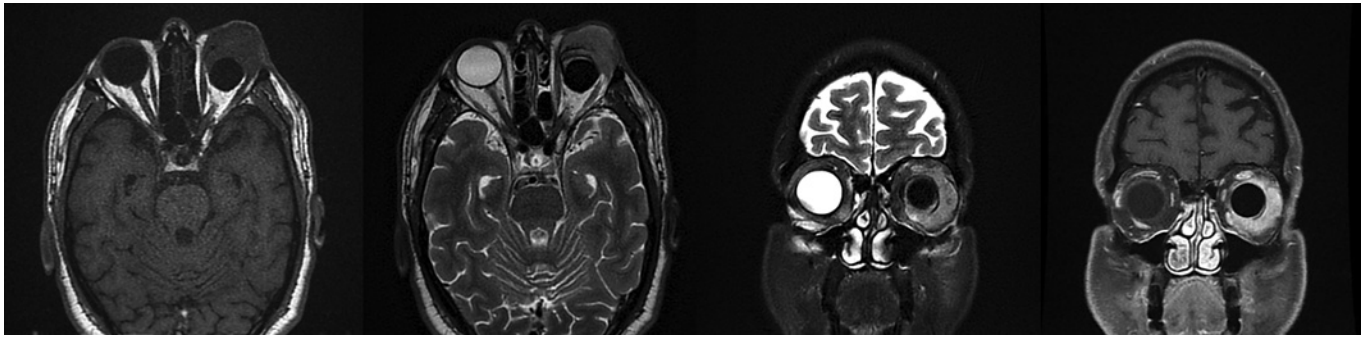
Patient 1, MRI: mass in the left orbit, located anteriorly to the implant. The lesion demonstrates low intensity on T1-weighted images, intermediate intensity on T2-weighted images, and high contrast enhancement.
